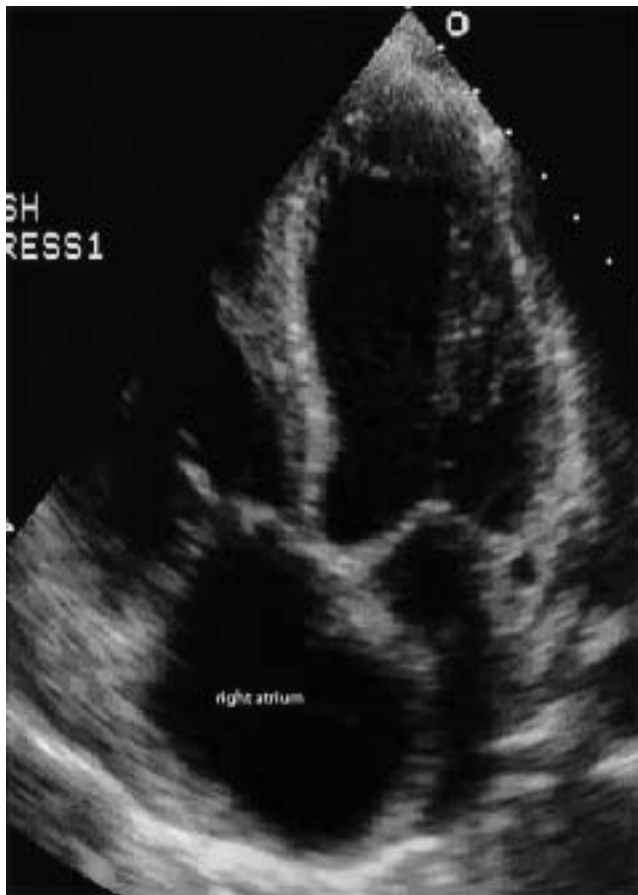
Transthoracic echocardiographic apical four-chamber view with prominent right ventricular hypertrophy and right atrial enlargement with a bowed intra-atrial septum related to pulmonary homograft stenosis.
